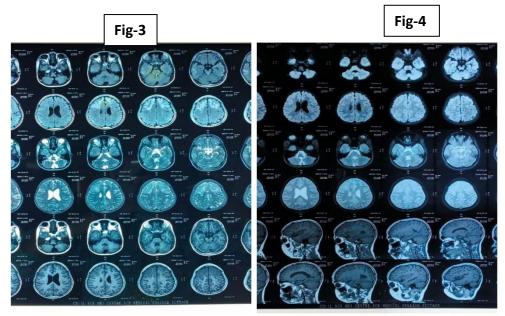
& Fig-4: MRI Brain Film:Diffuse Gyral Swelling WithT2wi/Flair Hyperintencity Noted Involving Bilateral Superior Frontal Lobe And Right Temporal Lobe Without Any Diffusion Restriction.
